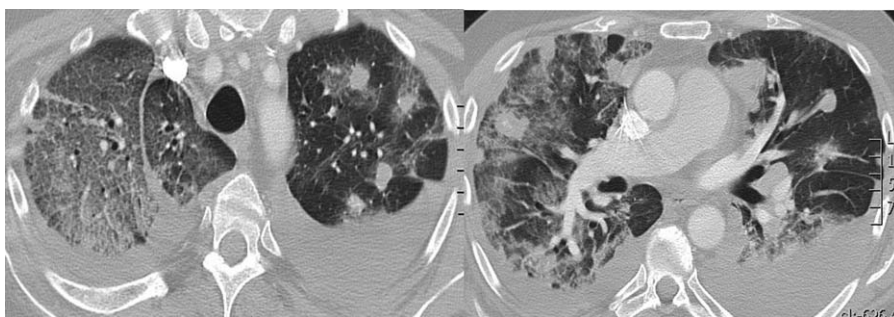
Patient 2. CT scan 2 months after the evidence of pulmonary progression shows the increase of pulmonary nodules, bilateral pleural effusion and wide ground glass attenuation, mainly in the right upper lobe.
